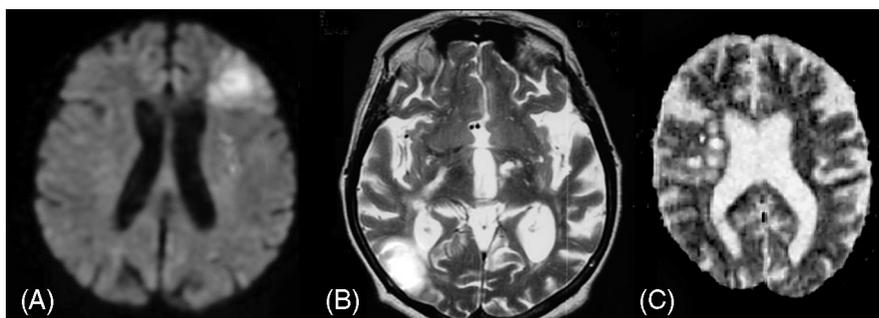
(A) Diffusion-weighted MRI of the patient with anterior borderzone infarction between the boundary zone of the anterior and middle cerebral artery. (B) Posterior borderzone infarction at the middle cerebral artery and posterior cerebral artery on MRI. (C) Subcortical low-flow infarction on MRI. The lesion is chain-like arrangement along the lateral ventricle.
